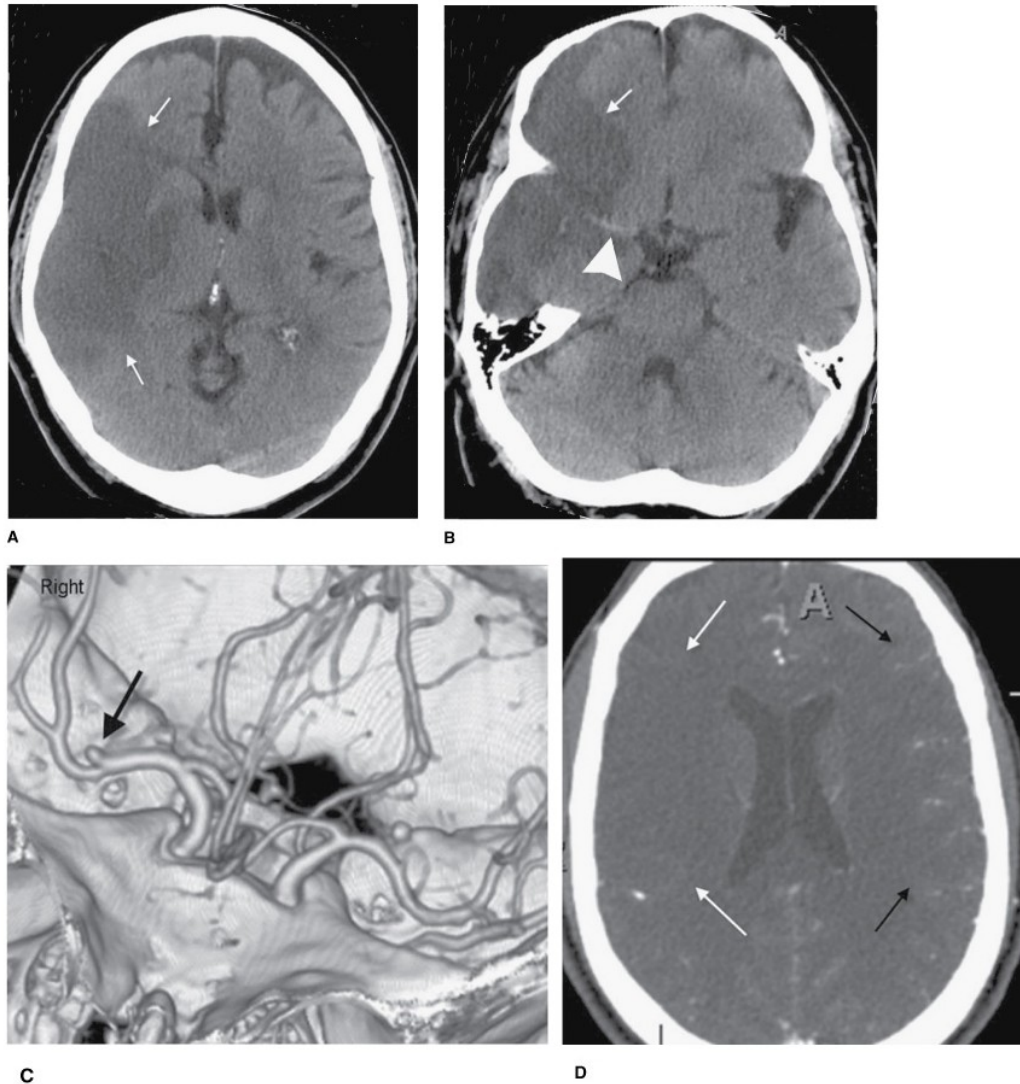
CT scan of a cerebral infarction in a 56 year old hypertensive and diabetic male who presented with left hemiparesis in the emergency department. A and B. Axial CT at 2 different levels without contrast injection showing a well-defined hypodense area in the right MCA territory (between white arrows) and a mass effect on the surrounding brain tissue (compression of right ventricle). The right MCA is brighter than the left (large white arrow head on B) and corresponds to an occluding thrombus. C. A 3-D volume rendering CT angiogram shows the occlusion in the superior branch of the right MCA. D. Axial CT with contrast injection shows decreased filling of blood vessels in the right MCA territory (between white arrows) compared to the left (black arrows). Images adapted from: Chen, Pope and Ott. *Basic Radiology*, 2nd edition, Chapter 12.
